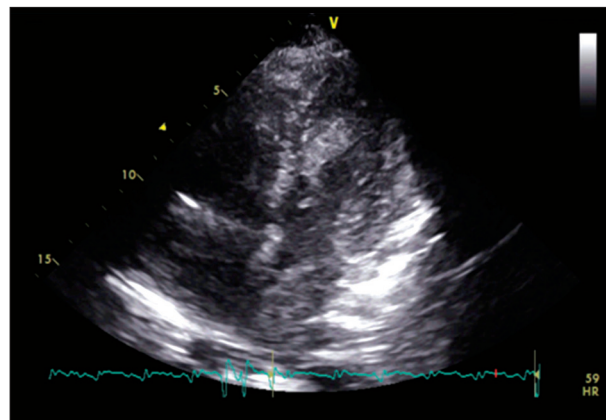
Intra-cardiac thrombi in both left atrium and left ventricle were noticed on apical 4 chamber view of echocardiography 24 hours after initiation of peripheral cardiopulmonary support.
